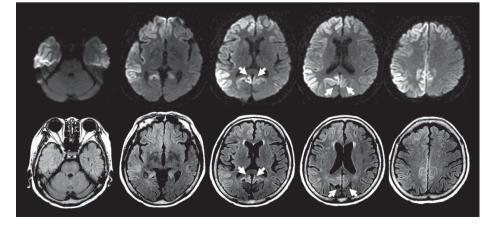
Diffusion weighted (upper row) and FLAIR (lower row) axial brain MRIs show high signal intensity in diffuse cerebral cortex with dominant involvement of right hemisphere. Cerebellum and medial occipital lobes posterior to the parietooccipital sulcus indicated by arrows are spared.
